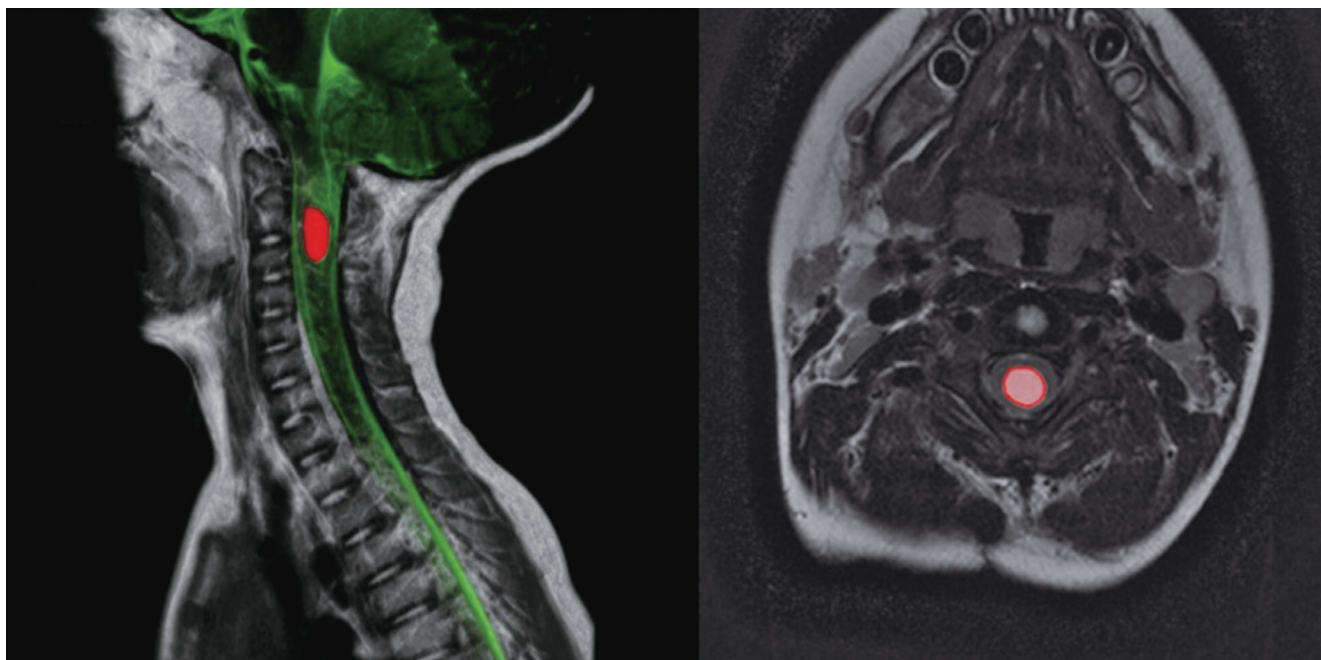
Sagittal and axial cut of the syrinx on MRI. The CSF area (green) was selected from the original image, and the syrinx area (red) was extracted using AVIEW (version 1.0; Coreline Soft). MRI, magnetic resonance imaging; CSF, cerebrospinal fluid.
